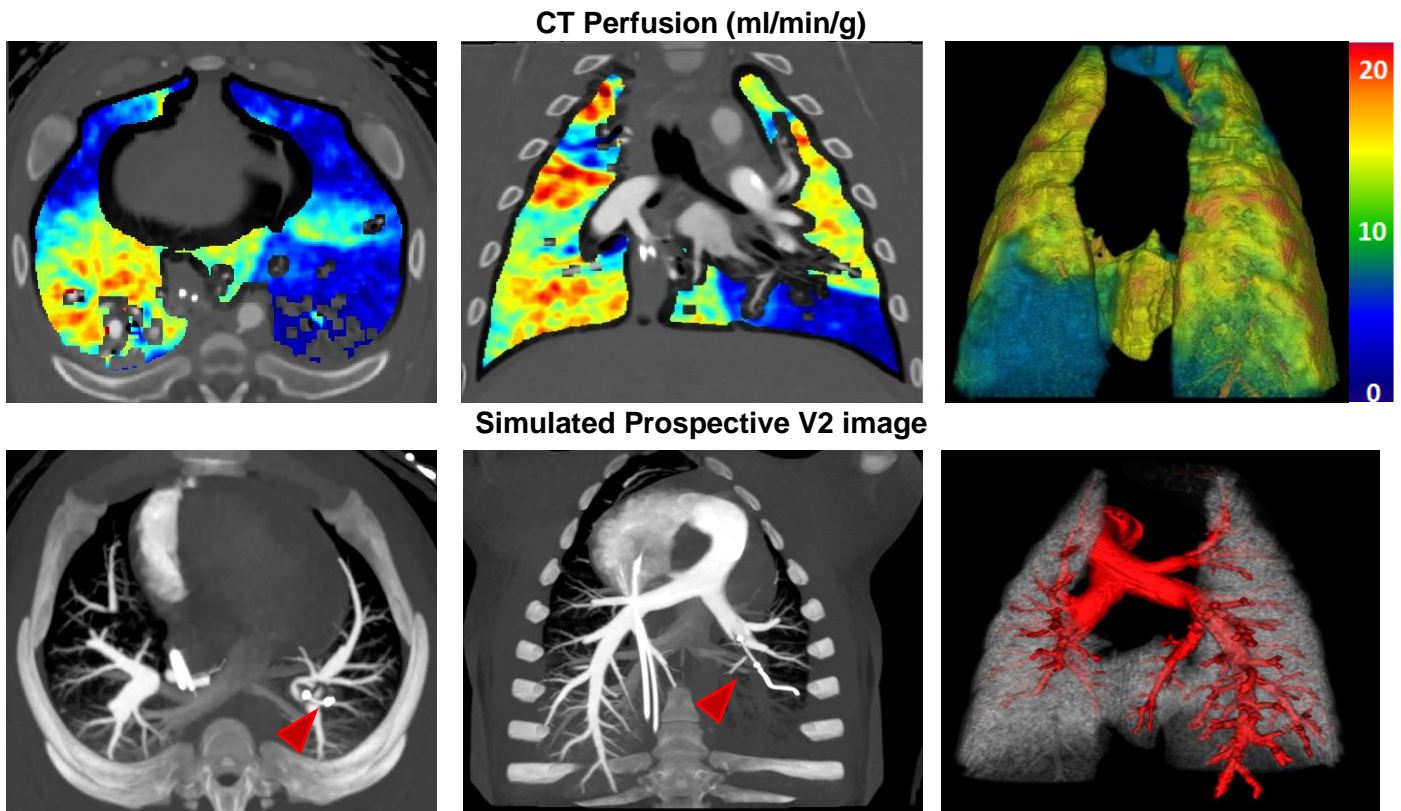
Two-volume dynamic CT perfusion maps and CT pulmonary angiography.
